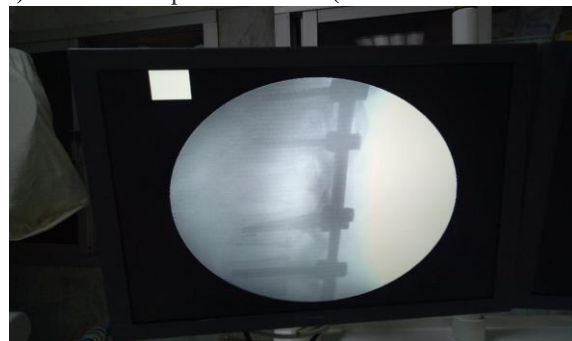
Postoperative radiographical images: Lateral view
